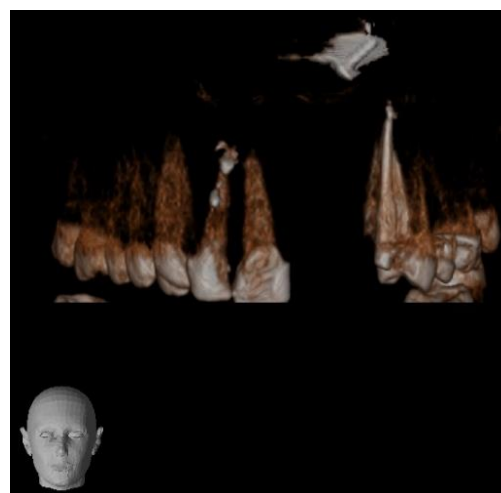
CBCT scan of entire maxillary arch.
